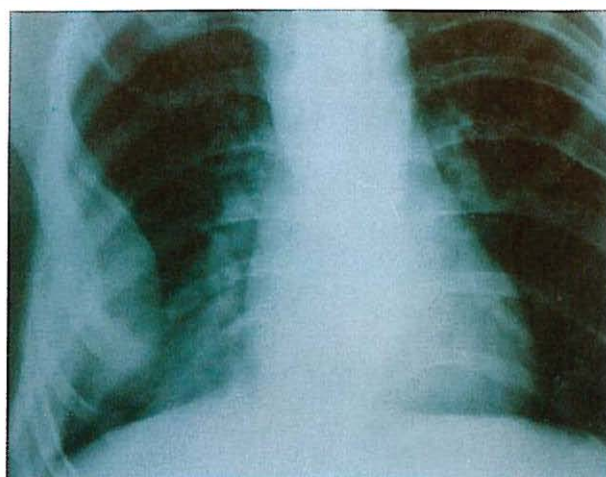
Chest x-ray shows a solid mass of the soft tissue of the right thorax with rib deformities.
